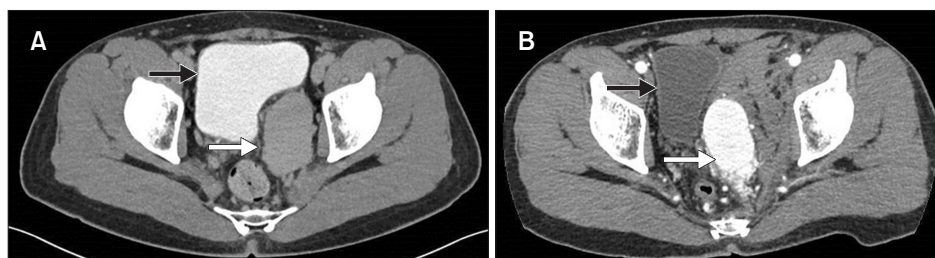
(A) Circumscribed left hemipelvis-enhancing mass was detected on the venous phase of computed tomography (CT) urography. (B) Corresponding image on CT angiography indicated that the left hemipelvic mass was actually a venous aneurysm of a pelvic arteriovenous malformation (AVM). A hematoma resulted from the biopsy, but no active contrast extravasation was seen. The black arrow indicates the bladder, while the white arrow indicates the AVM.
